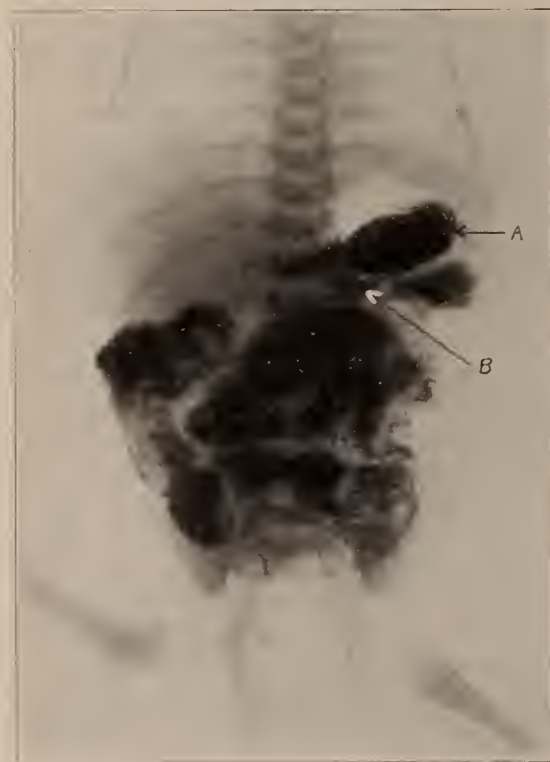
Roentgenogram 18 hours after ingestion of barium meal showing (A) gastric retention and (B) obstruction probably in jejunum.
